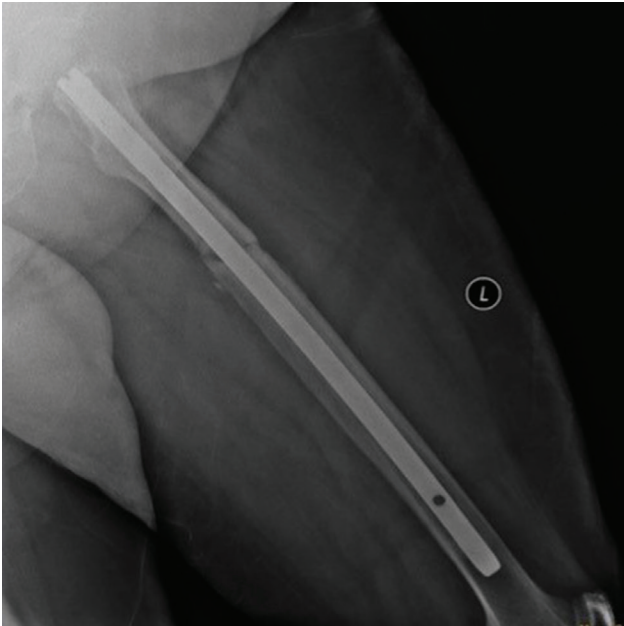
Radiograph of the first fracture of the patient on the left femur taken one year after open reduction and internal fixation.
